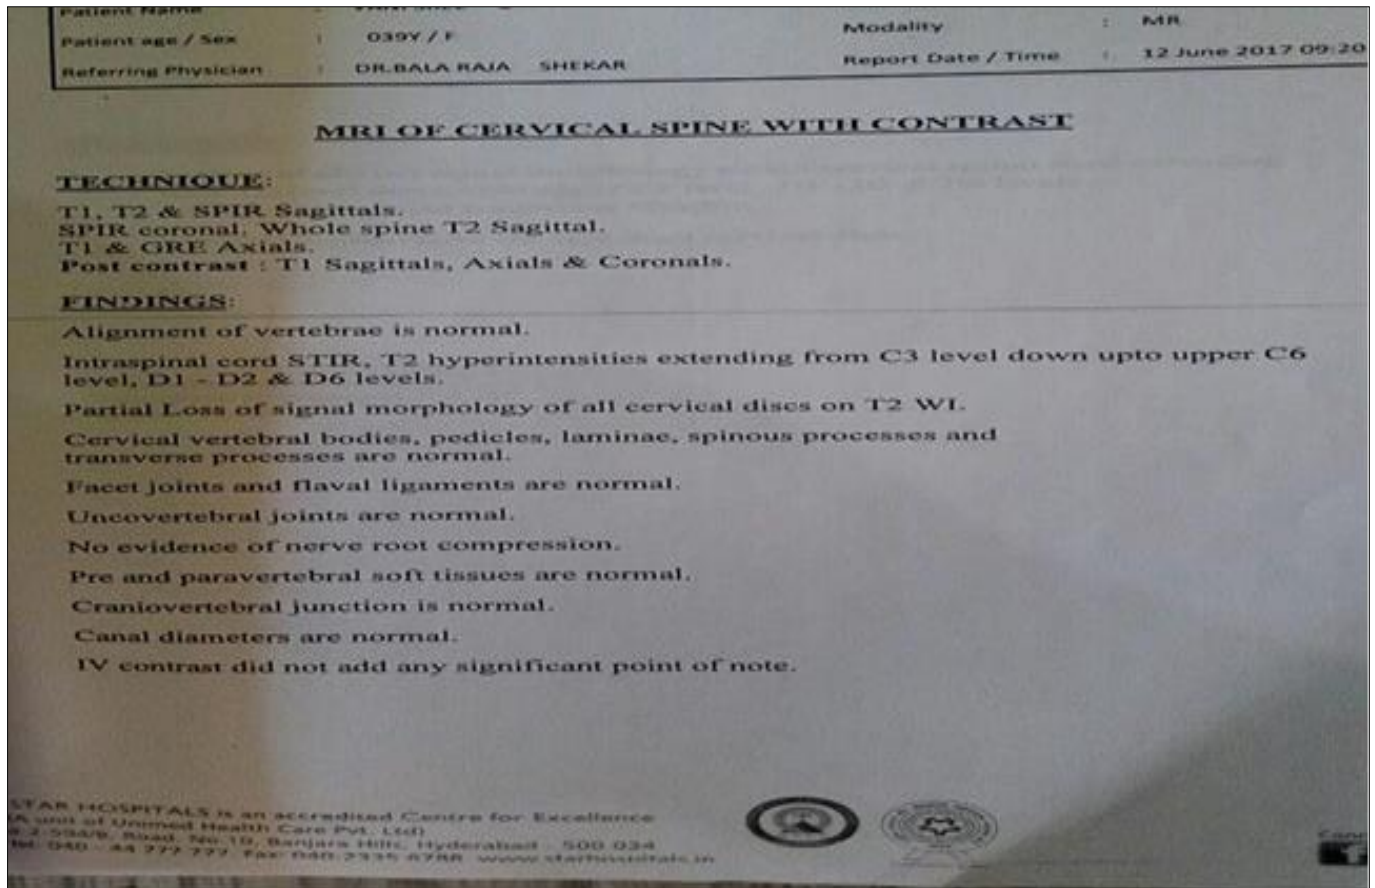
MRI findings (Report taken on 12/June/17)
